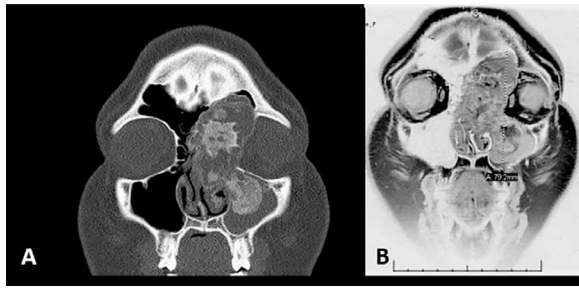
(A) Coronal computed tomography showing expansile mixed lesion with calcified matrix involving the left side of maxilla, maxillary sinus, nasal cavity, paranasal sinuses and intracranial cavity. (B) Coronal magnetic resonance with enhancement showing heterogeneously enhanced expansile mass.
